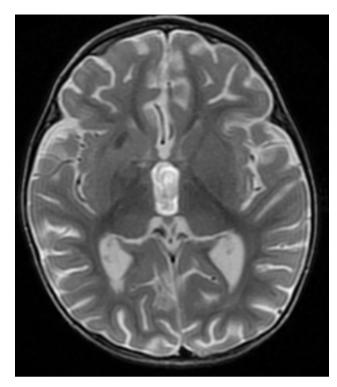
Contrast-enhanced brain magnetic resonance imaging showed meningeal enhancement, a reduced measures of the spaceoccupying lesion in the subcortical white matter, abnormal enhancement of basal cisterns and decreased diameter of the focalised lesion of the right internal capsule knee.
